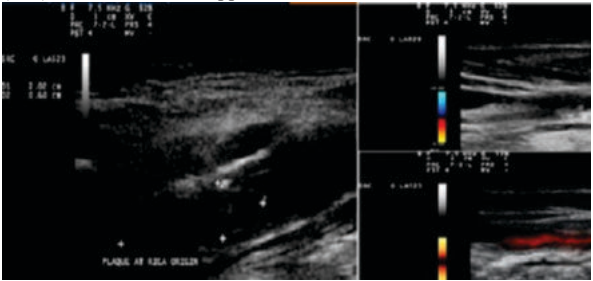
Gray scale sonography image showing hypoechoic irregular plaque at Right ICA origin, Colour doppler image showing absent colour flow in distal part, Same image on power doppler showing presence of colour flow.
